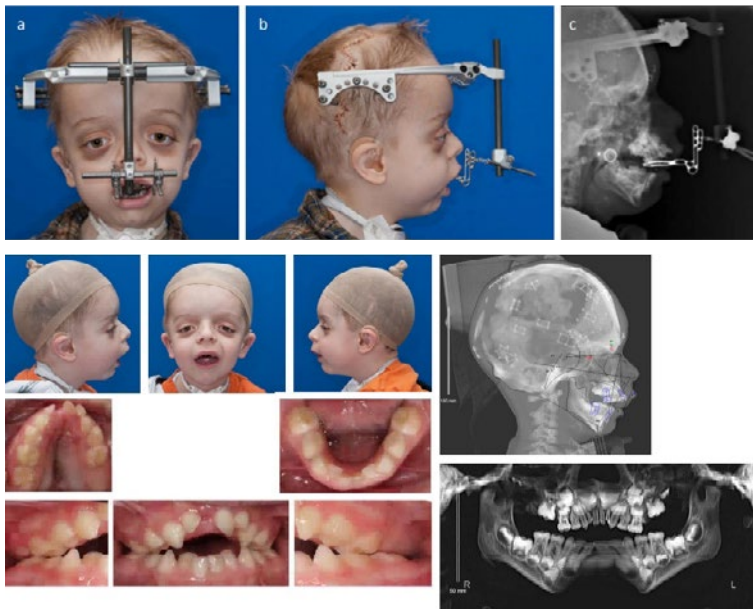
Case 1 - 6 years of age. (a, b, c) Facial photographs and a lateral cephalometric radiograph obtained during the consolidation phase of Le Fort III distraction osteogenesis (DO). (d) Clinical photographs and radiographs following removal of appliances and prior to beginning limited orthodontic treatment.
